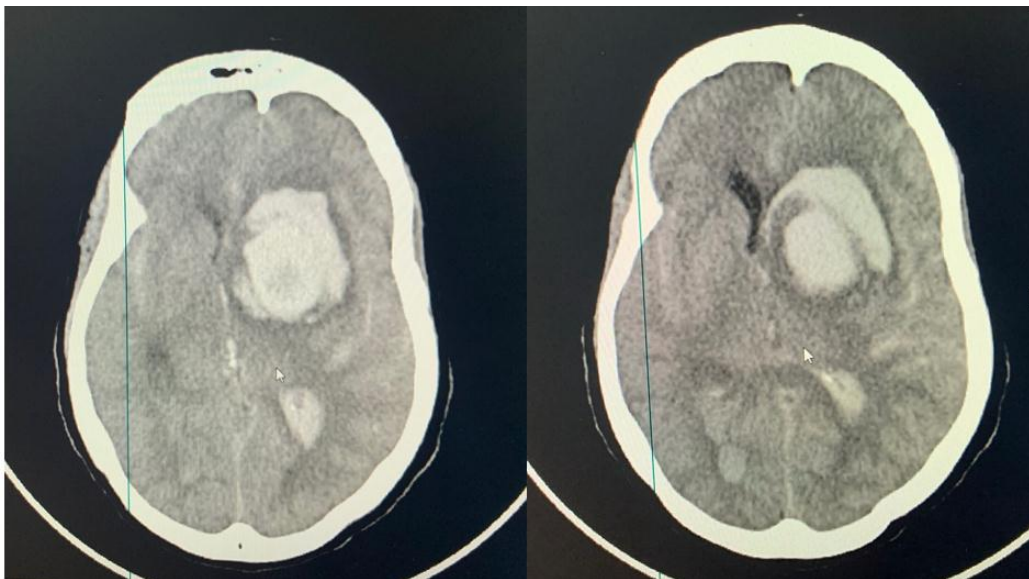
Non-enhanced Brain CT of a 44-year-old female in axial plane. The images demonstrate a hyperdense lesion in the right basal ganglia. There is perilesional hypodense area that depicts edema and midline shift due to mass effect. Intraventricular hemorrhage is seen in the ipsilateral lateral ventricle and subarachnoid hemorrhage.
